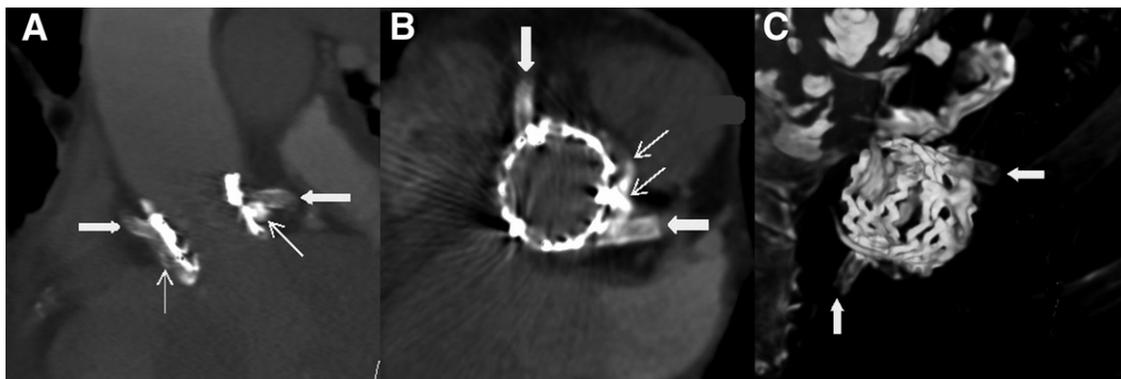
Computed Tomography at Hospital Discharge
